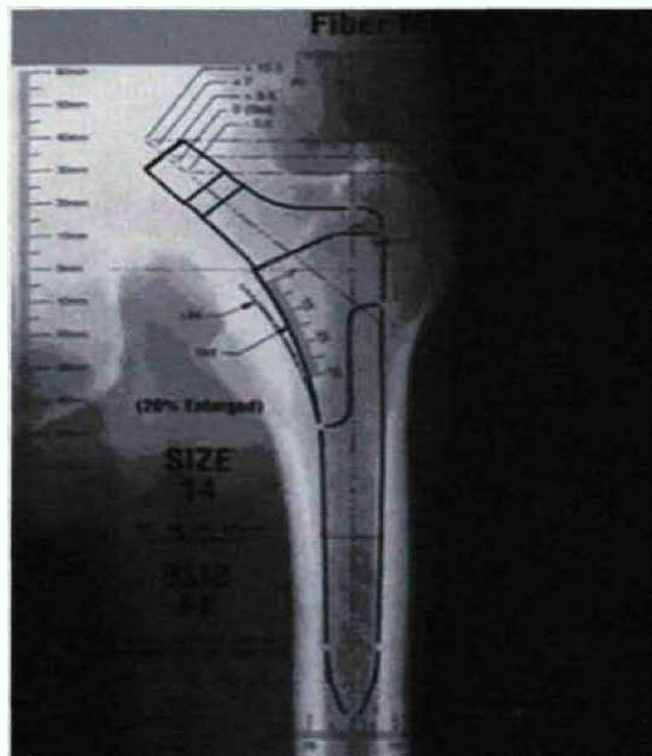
Preoperative planning based on radiographs using templates.
